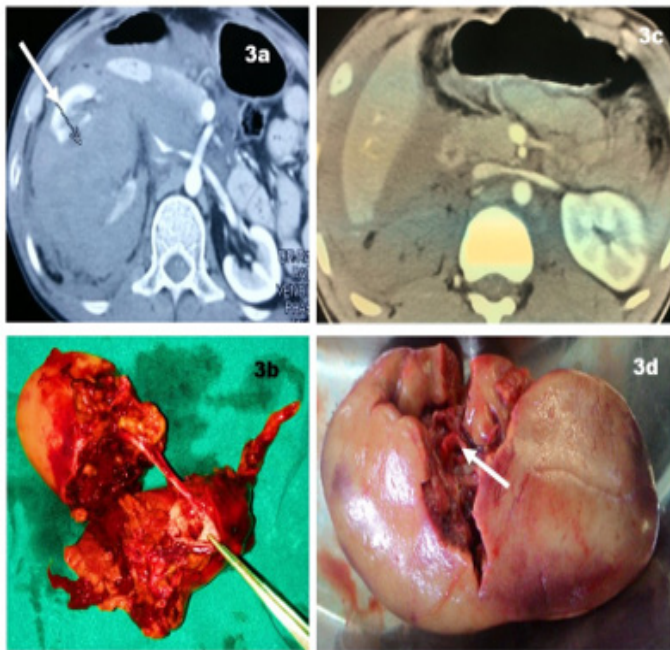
CT scan done in a 55-year-old male pt. shows Grade V injury to the Rt. kidney and no perfusion of the Rt. kidney. Areas of contrast leak suggestive of renal artery injury seen.
